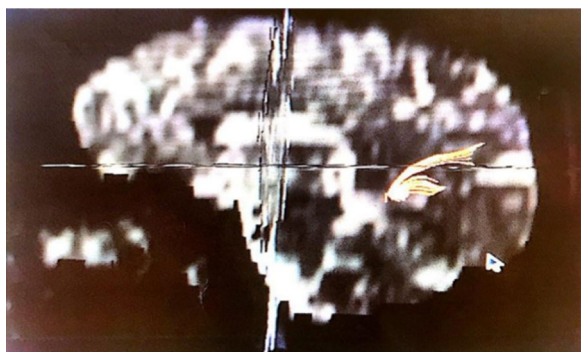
MRI Sagittal view diffusion tensor imaging (DTI) with generation of color diffusion tractography of the AF (non-reconstructed AF)
